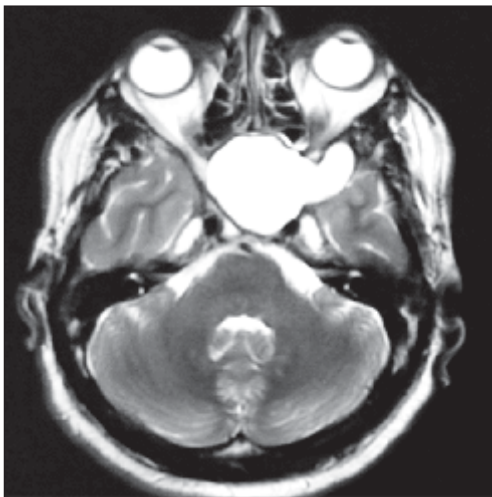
MRI Axial cut T2 weighted image showing mucocele in sphenoid
